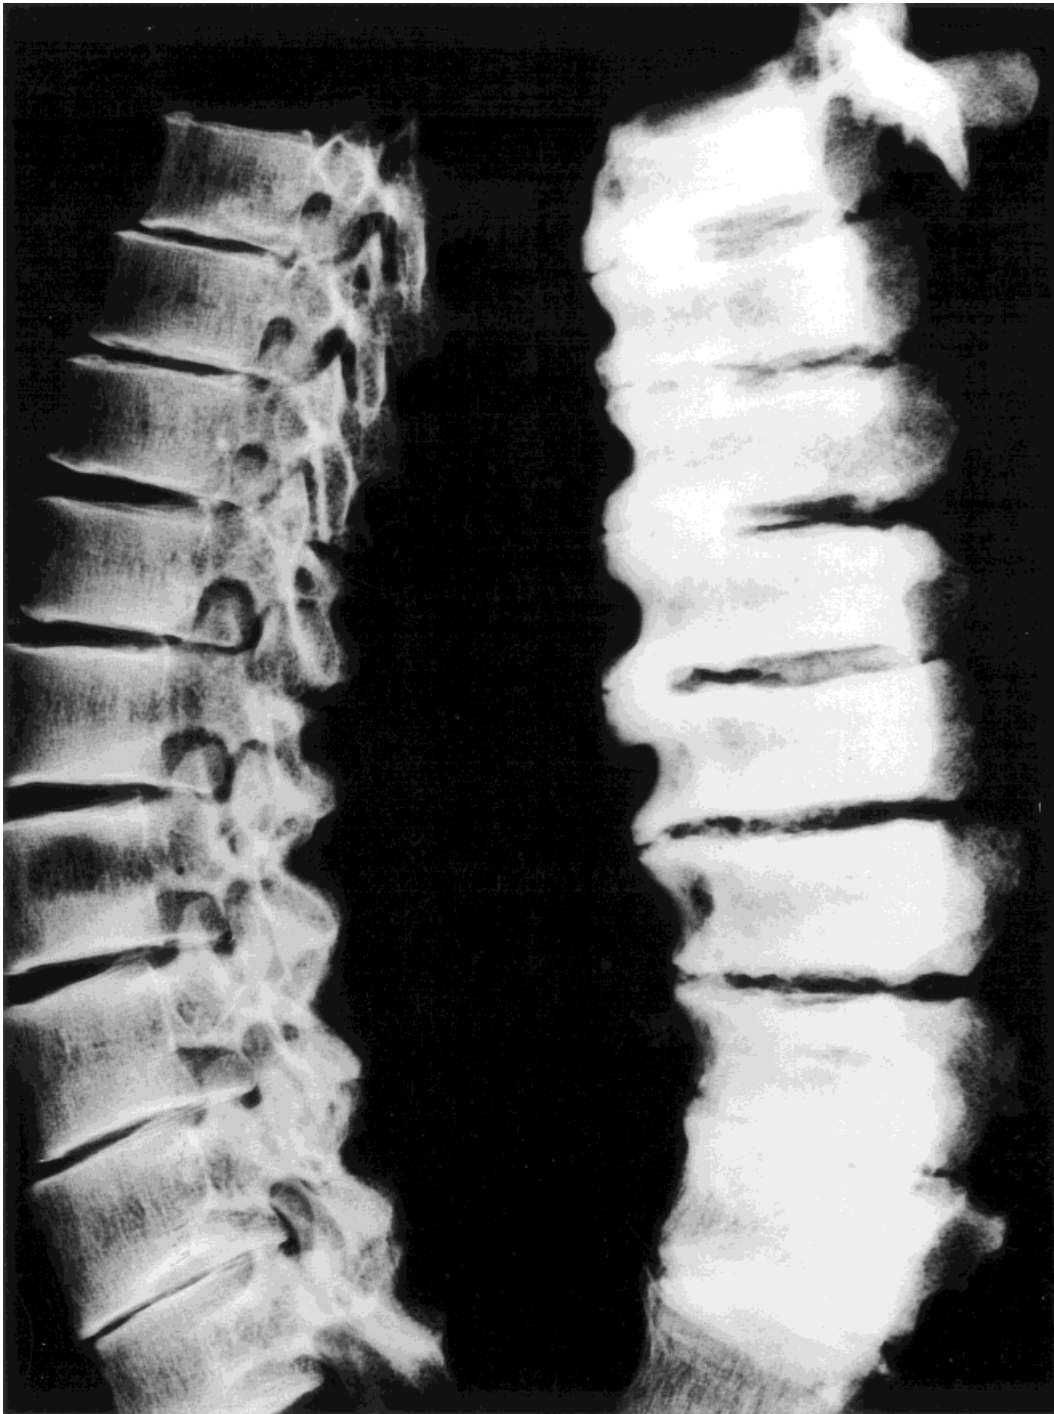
X-ray of affected spine (right) compared to normal spine from DS3 (left).
